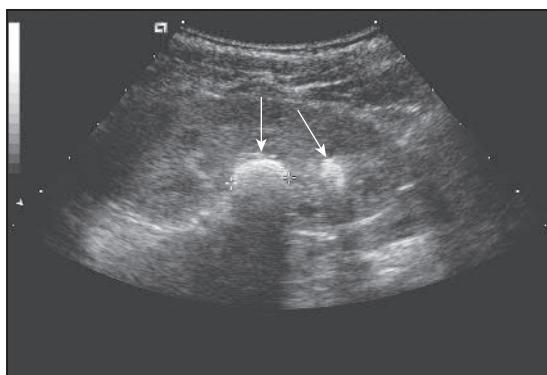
Renal ultrasound showing a staghorn calculus (arrows).
